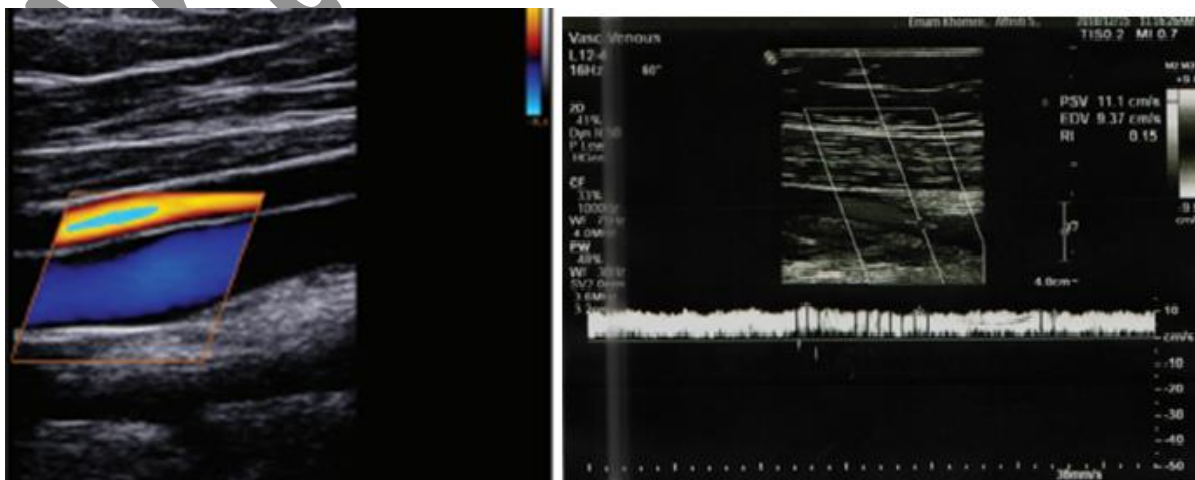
Ultrasound Image of a 35-Year-Old Person's Vein
